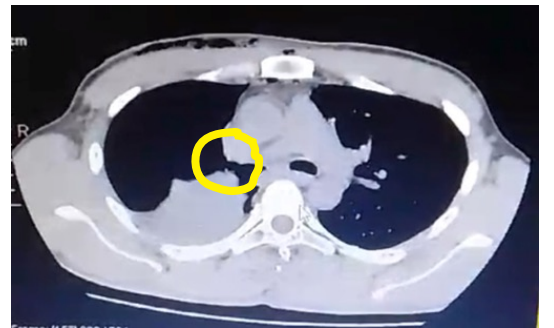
CT chest revealed collapsed right lung and Right Main bronchial Disruption.
